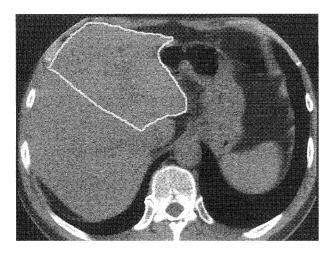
Estimated CT-scan volumetry of left hemiliver graft including the middle hepatic vein (OLT 965).
